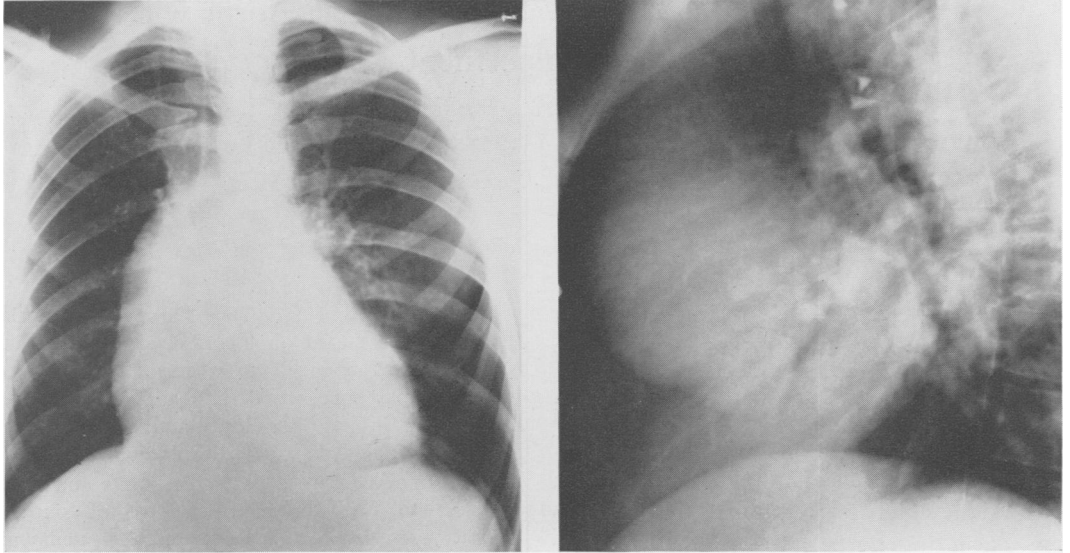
Case 1. 35-year-old man with chest pain, fever, weight loss, recently noted cardiac murmur. (a) (left) Roentgenogram showing enlargement of ascending aorta with prominent left ventricle. (b) (right) Lateral angiogram demonstrating aneurysm arising just above the sinus of Valsalva. Note normal size of valve ring and sinuses of Valsalva.
